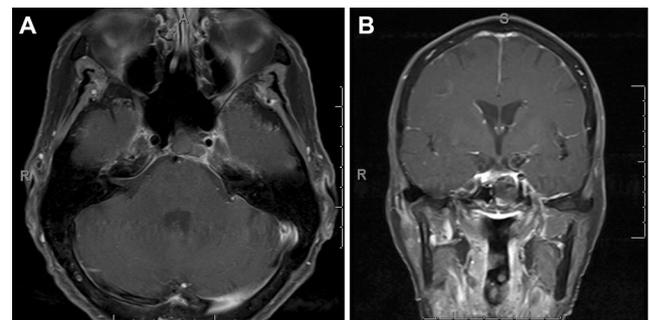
Follow-up a axial and b coronal MRI with gadolinium of the brain 8 months postoperatively demonstrating marked improvement of the enhancement with residual postoperative changes
